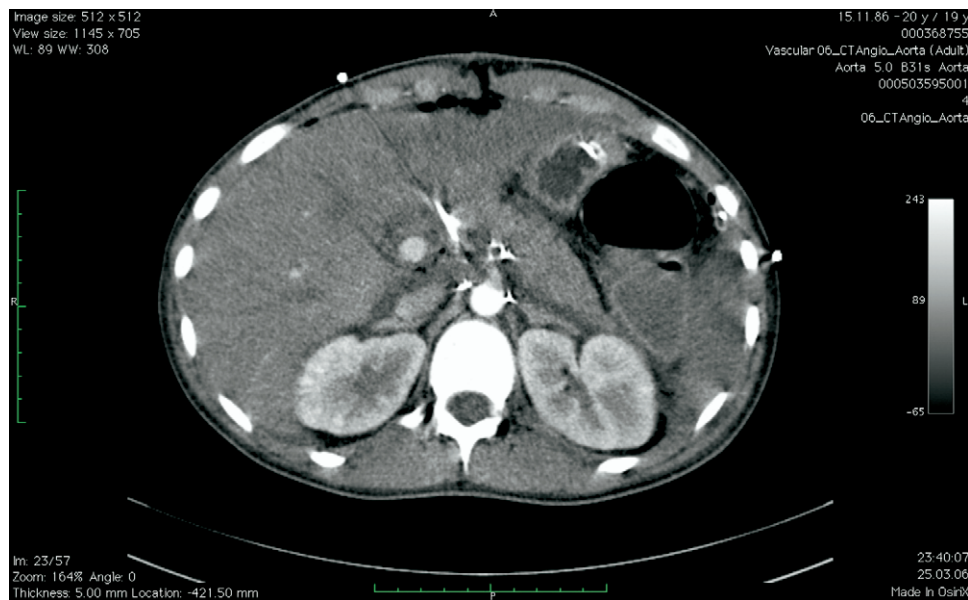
Computed tomography scan on first postoperative day shows rethrombosis of celiac trunk.
